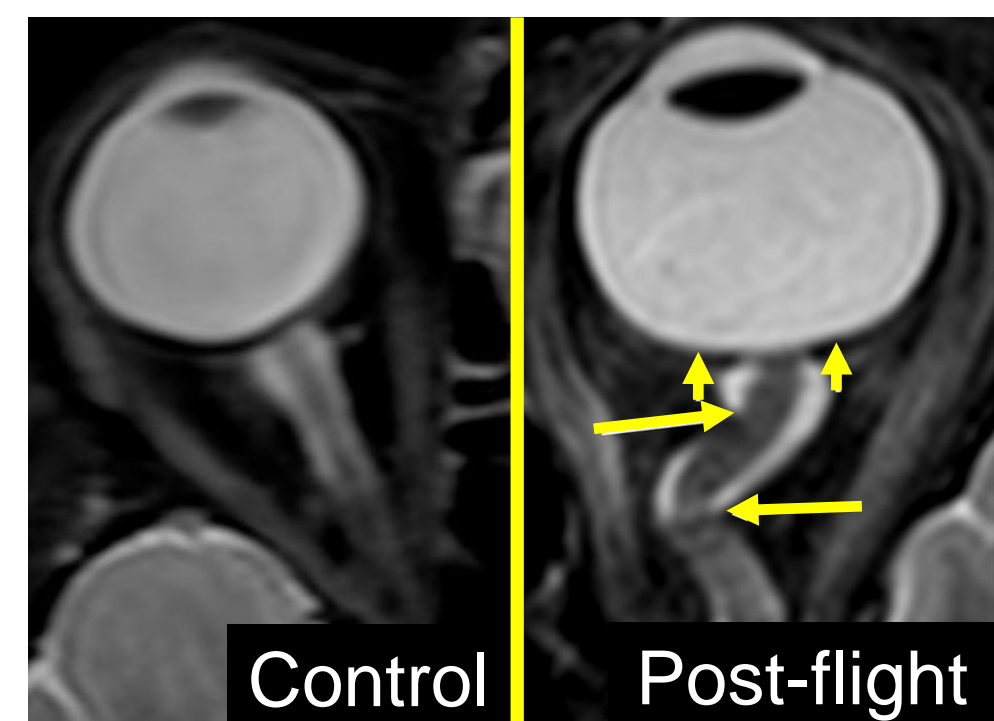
Left: MR image of a normal eye and optic nerve. Right: MR image of an eye from an astronaut with VIIP, showing 'kinking' (long arrows) of the optic nerve and posterior globe flattening (short arrows)².
